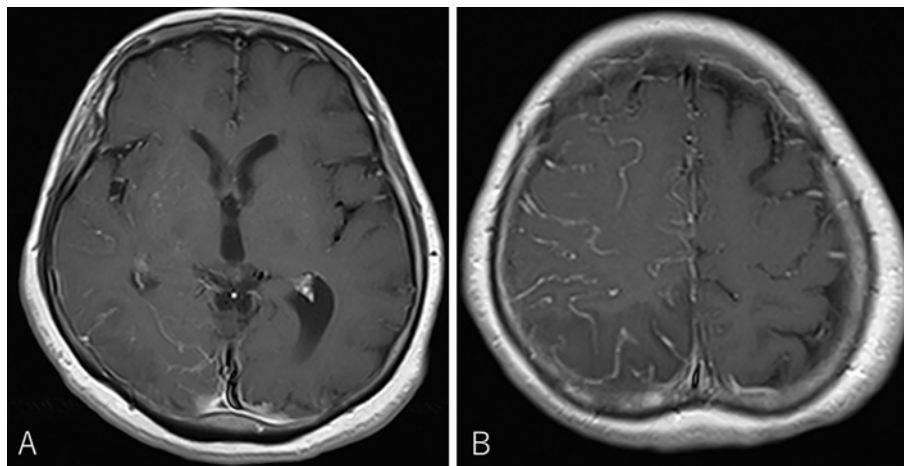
Gd-enhanced T1-weighted MRI (A, B) five days after admission reveals enhancement in the subarachnoid space corresponding to hyperintensity on FLAIR imaging.
